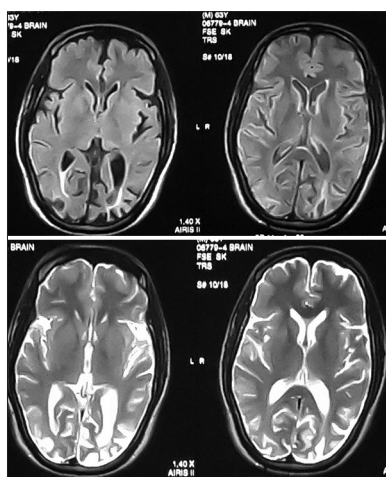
Magnetic resonance imaging brain shows prominent cortical sulci in bilateral occipital lobes with prominent occipital horns with mild periventricular hyperintensities on T2-weighted and fluid-attenuated inversion recovery images
